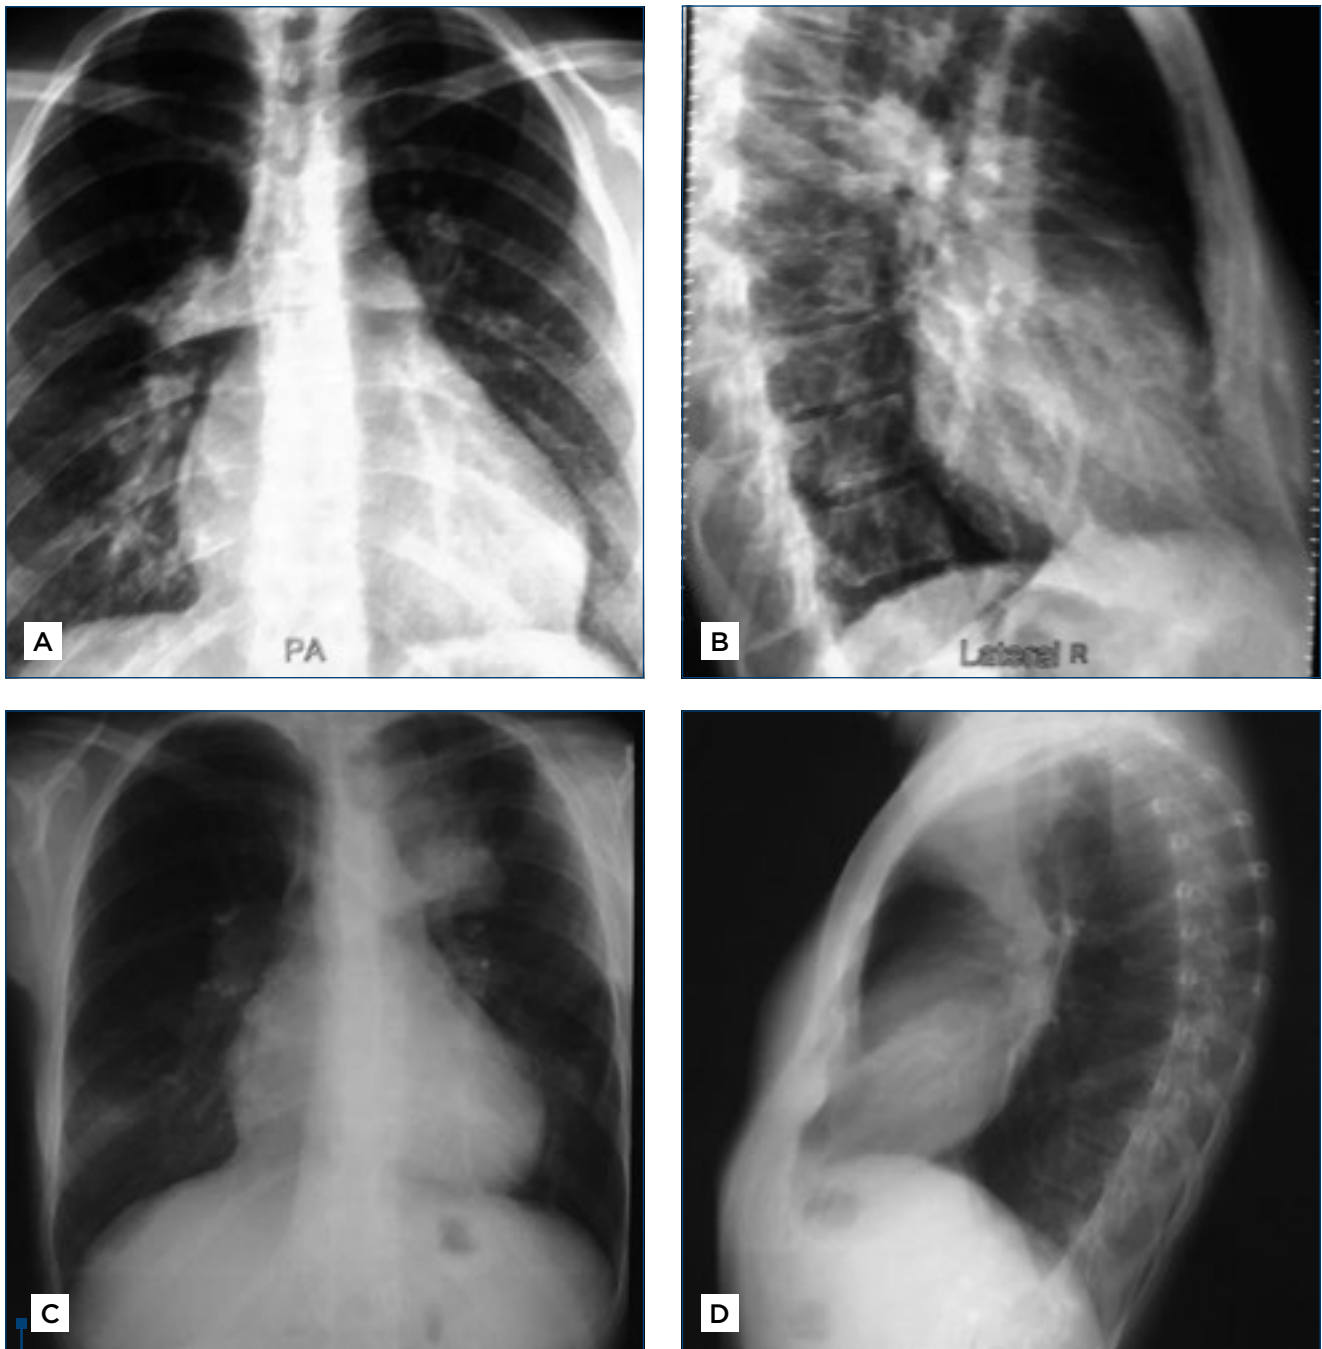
Chest radiography: A, B in June (2013) bilateral nodular opacities on the right in S2, S6, S10 and in left S2; C, D in January (2014) on the left the opacity extended in S1, S3
